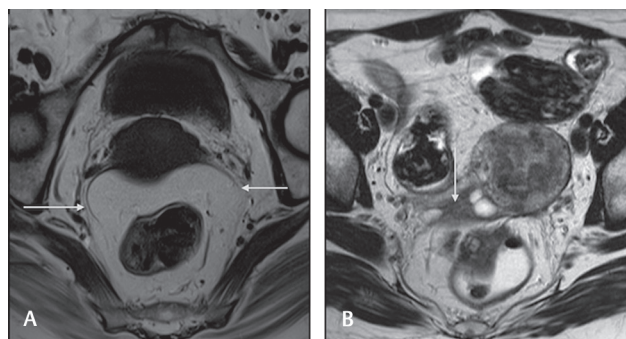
(A, B) T2W oblique axial image (A) showing the normal uterosacral ligaments (*arrows*) and the thickened ligament on the right side with cystic areas within it (*arrow* in B). T2W, T2-weighted.
